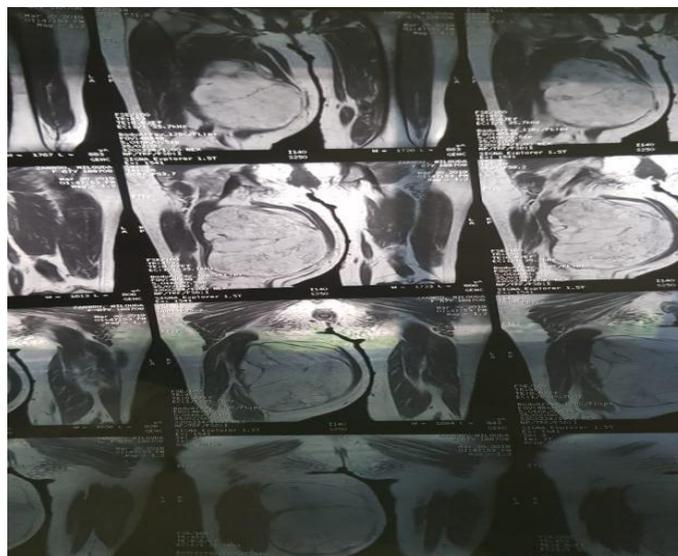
MRI Image of the giant lipoma, frontal view showing a voluminous tumor with high signal in T1 and T2.
